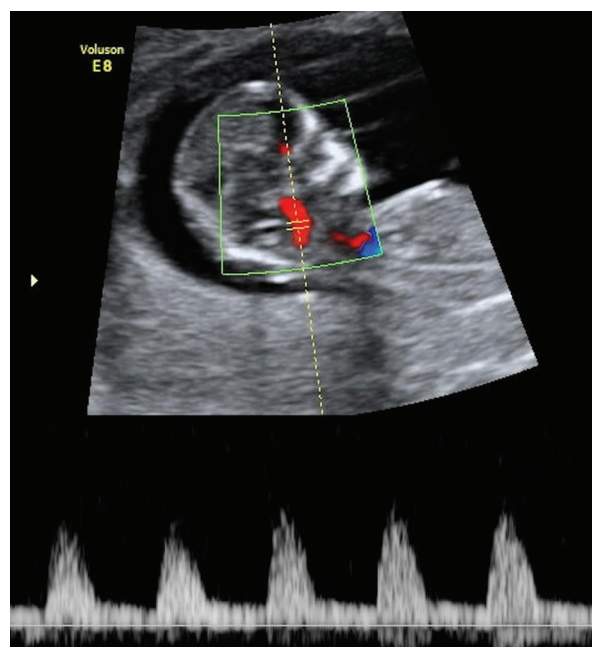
Transabdominal insonation of the basilar artery (BA) at the first trimester. The BA was identified along the sagittal plane anterior to the brainstem using color Doppler ultrasound.
